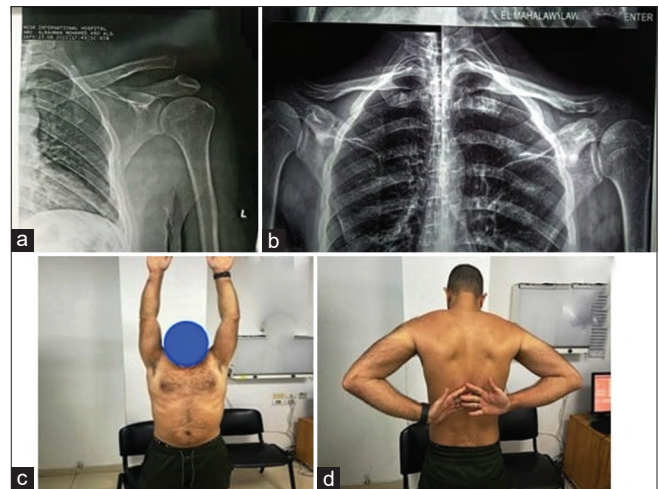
(a) Preoperative X-rays showing acromioclavicular joint (ACJ) dislocation, (b) postoperative X-ray ACJ reduced and (c and d) last range of motion of the same patient underwent AC reconstruction with Hamstring tendon autograft 9 months postoperative
